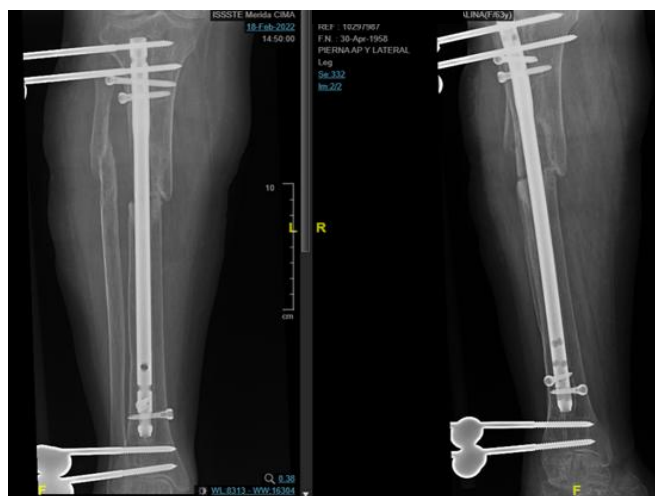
X-Ray 8 Months After Second surgery
